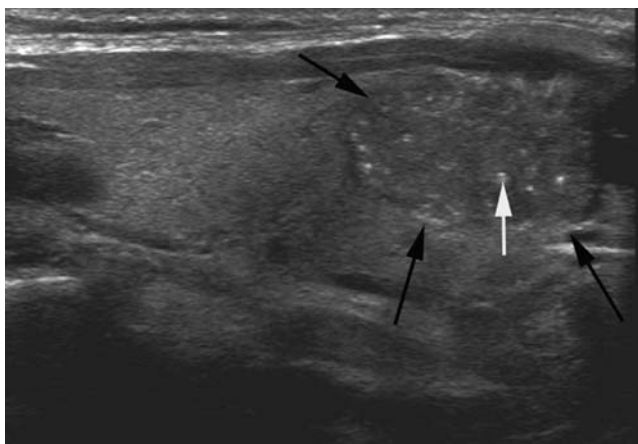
Thyroid carcinoma on ultrasound. Sagittal ultrasound image of the right thyroid lobe demonstrates a hypoechoic mass in the lower pole (*black arrows*). There are multiple hyperechogenic foci which represent psammomatous calcifications (*white arrow*)
